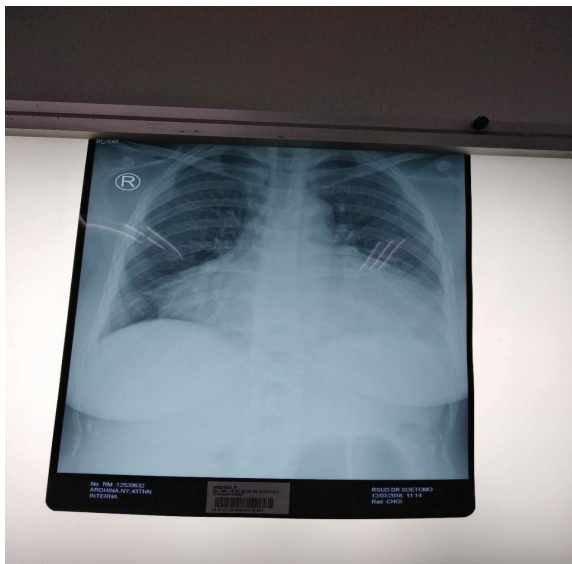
Chest xray show water bottle sign
